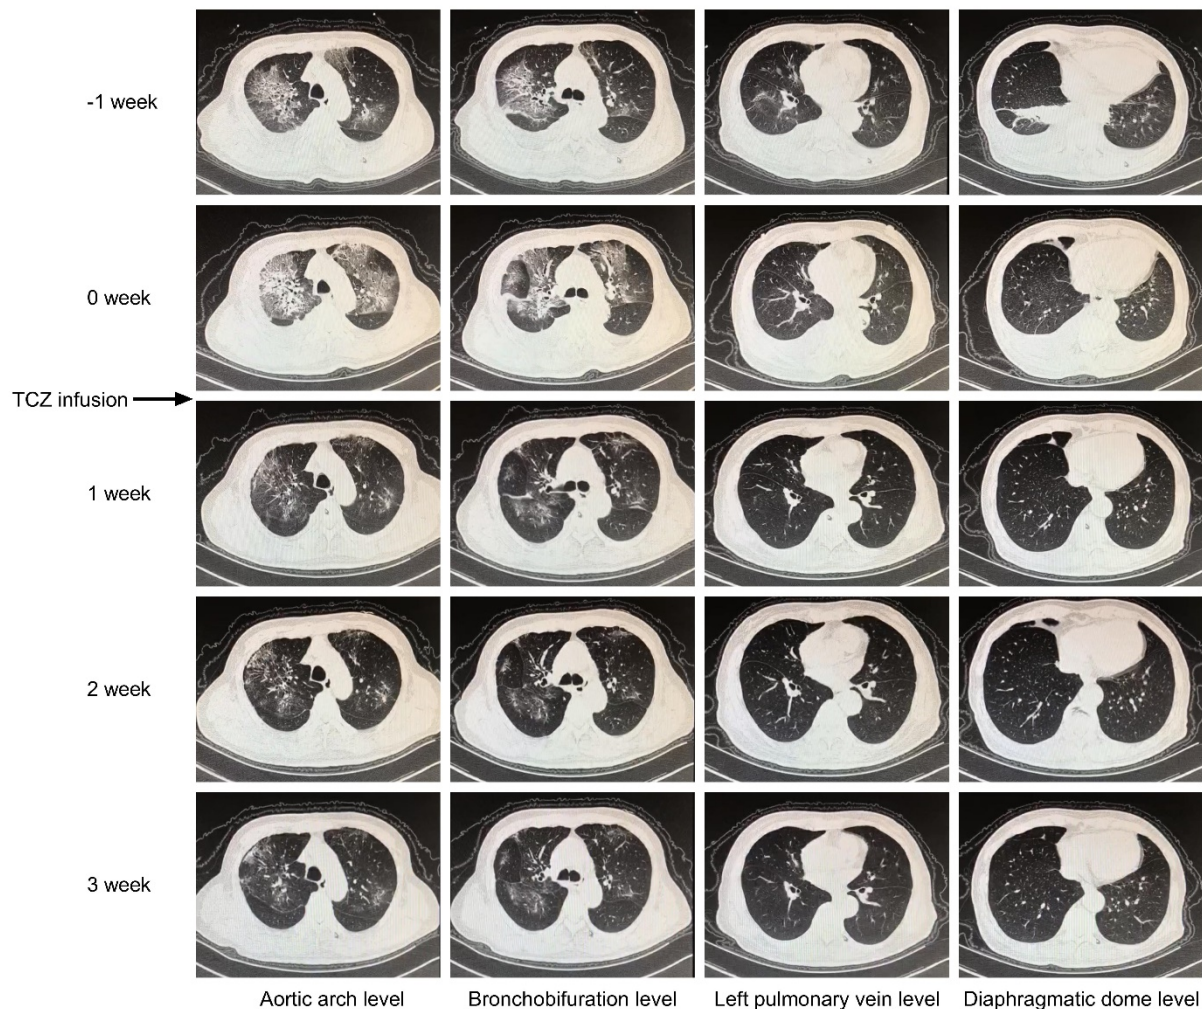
The computed tomography findings of one patient (No.5) before (week -1, 0) and 1, 2, 3 weeks after TCZ administration, respectively. After the comprehensive treatment together with TCZ, the ground-glass opacity lesions were largely absorbed, while some of the fibrosis stripe lesions were left. TCZ: Tocilizumab 268x206 mm (300 x 300 DPI)
